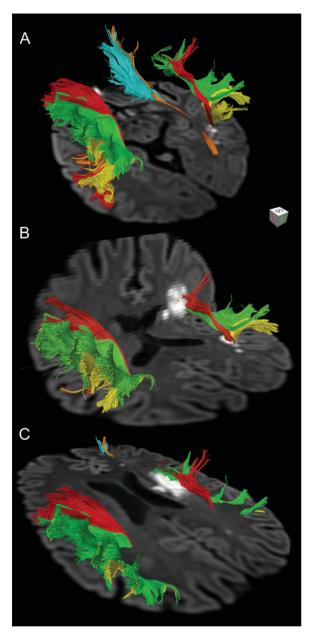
Virtual dissection with DTI MR tractography showing the trajectories of the three segments of the bilateral AF, right IFOF, and right UF projected over axial diffusion-weighted MR images at the level of the midbrain (A), splenium of the corpus callosum (B), and corona radiata (C). Note the relationship of the acute infarcts with the right AF at multiple levels. Ischemic infarcts have involved the long and posterior segments (A, B), the corona radiata and the anterior segment of the AF (C). Virtual dissection of the three segments of the AF shows moderate asymmetry of the direct segments with the left-sided AF being larger than the right-sided one (see Catani et al., 2007; Thiebaut de Schotten et al., 2011). The fasciculi are color-coded: AF segments (long, red; anterior, green; posterior, yellow); IFOF (orange), and UF (cyan). [To view this figure in color, please see the online version of this journal].
